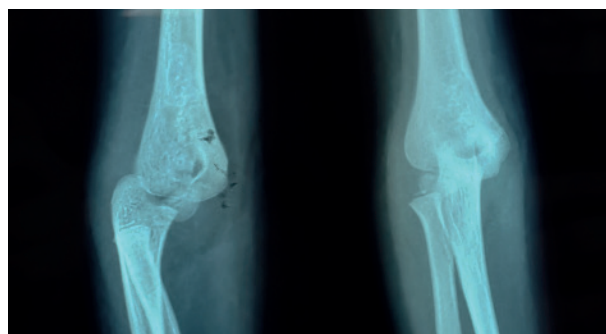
Lateral and Anteroposterior radiograph in preoperative
